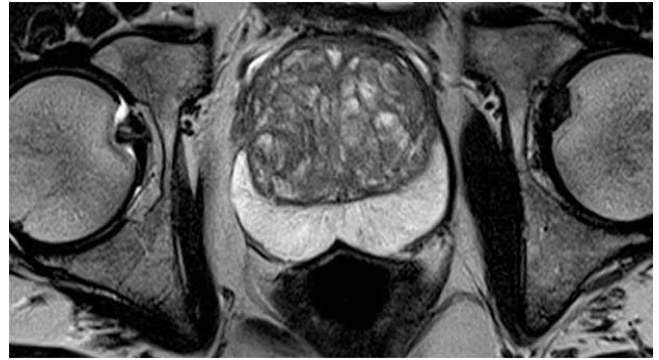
MRI of the Prostate cancer
